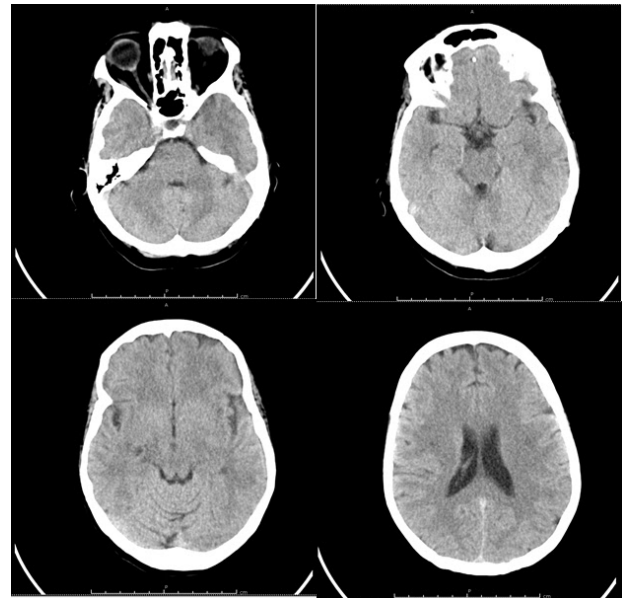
Brain CT scan images without abnormalities (case 1).
